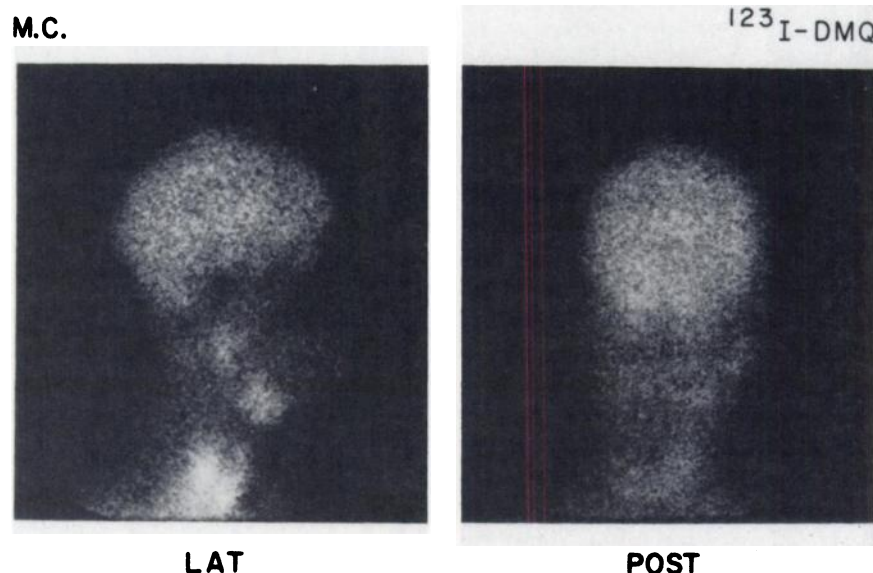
Brain scintigrams of patient at 6 hr after i.v. administration of 5 mCi of I-123 4-(3-dimethylpropylamino)-7-[I-123]iodoquinoline.
